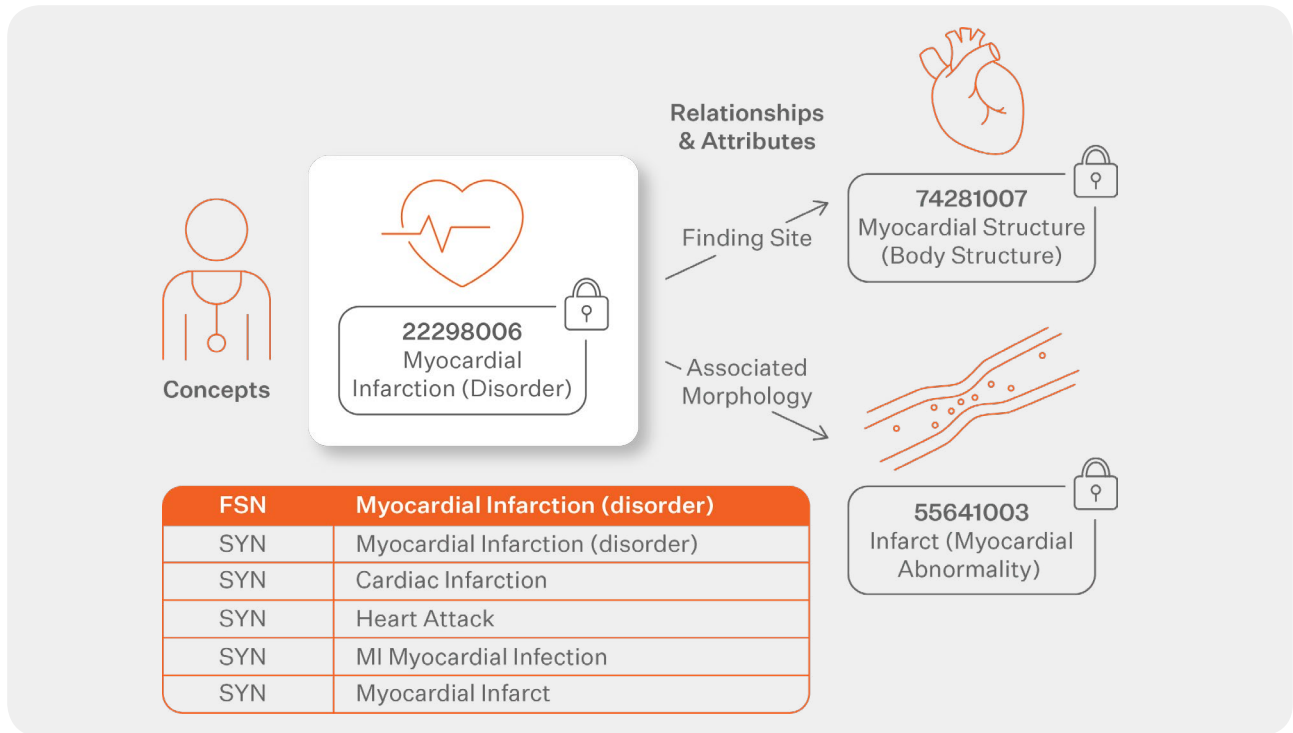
SNOMED-CT Concept Example
